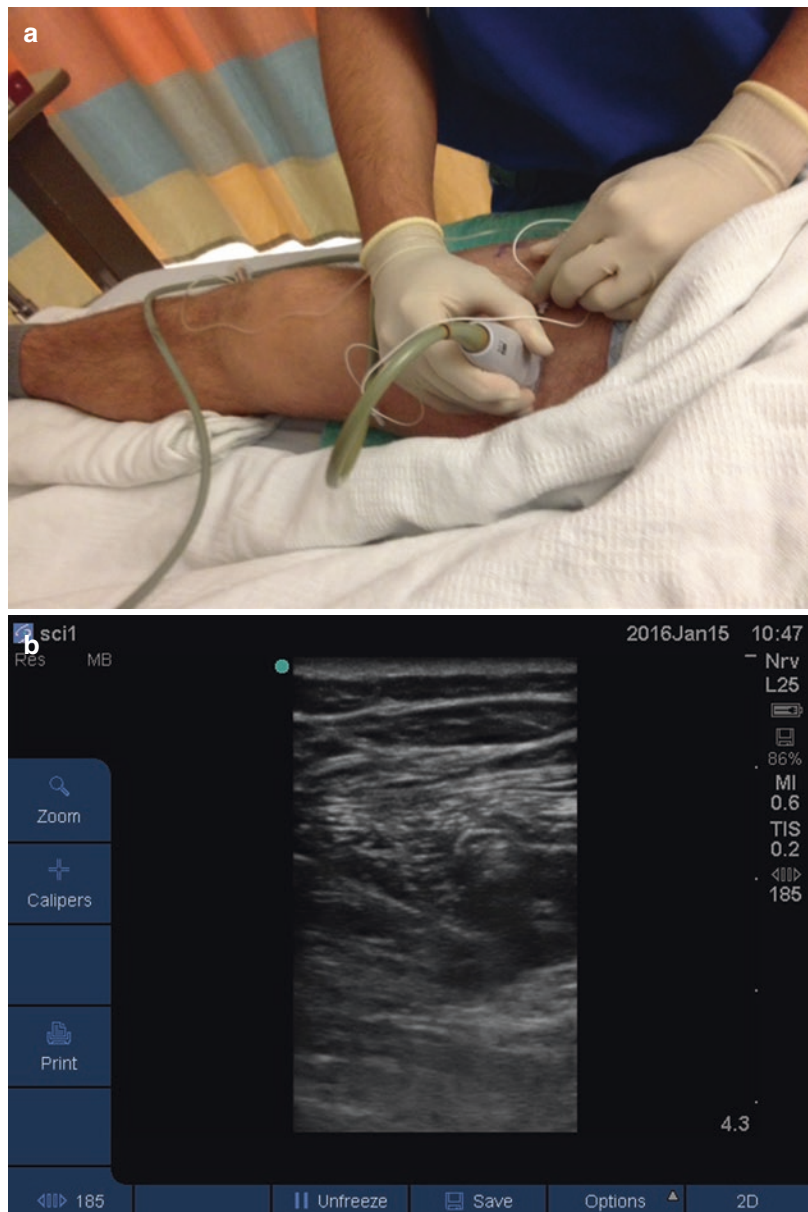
(a) Use of ultrasound guidance to perform adductor canal block. (b) Ultrasound image of needle adjacent to saphenous nerve and femoral artery in the adductor canal, before injection of local anesthetic
